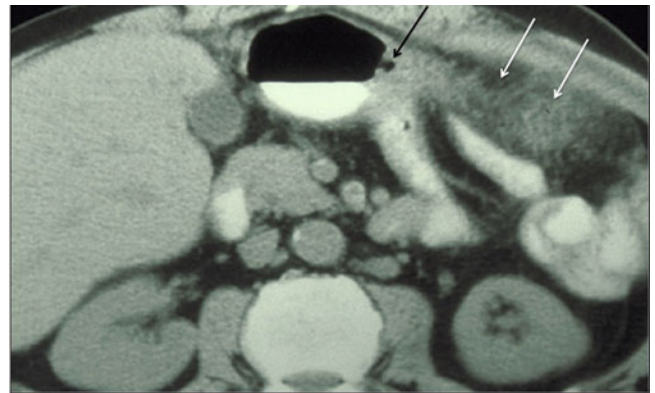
Transaxial computed tomography (CT) image through the gastrocolic ligament (*GCL*) demonstrates a gastric ulcer extending into the *GCL* (*black arrow*) with associated inflammation in the greater omentum (*white arrows*)
